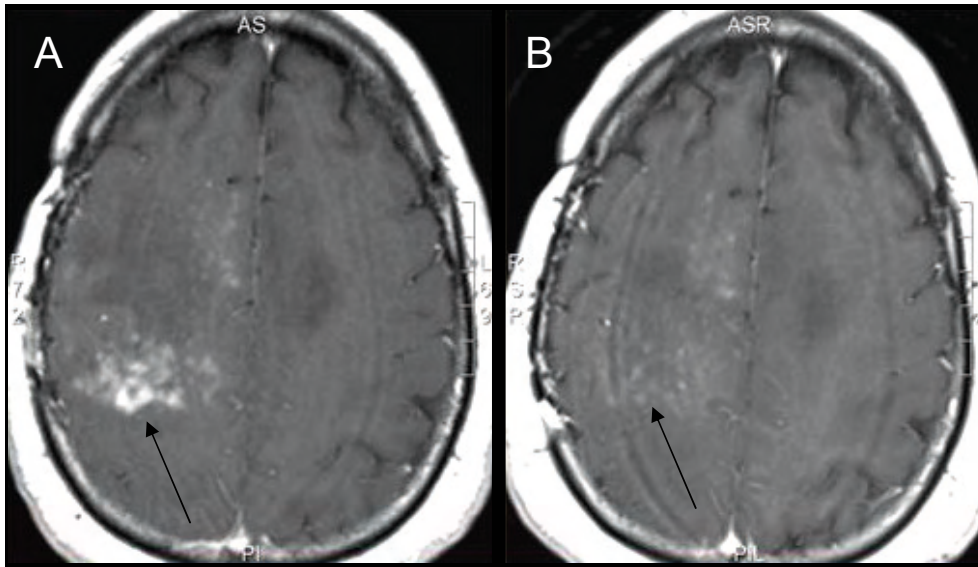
a) Pre-treatment CE-T1 MRI scan of a patient (PR) treated with bevacizumab and metronomic-dose TMZ; postmortem analysis showed an extensive infiltrative disease with tumour cells spreading into the contralateral hemisphere; b) during treatment, 4 weeks prior to CE-T1 MRI, the primary tumour site showed almost no contrast enhancement.
